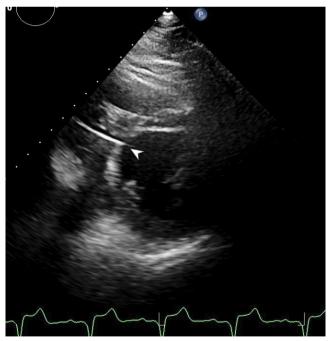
Parasternal short axis echocardiographic view showing the lead tip (white arrow) reaching the LV endocardium.
